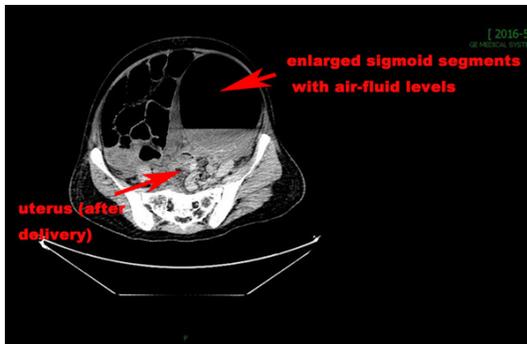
CT scanning shows enlarged sigmoid segments with air-fluid levels. The uterus and the enlarged sigmoid segments were indicated by the red arrows.
